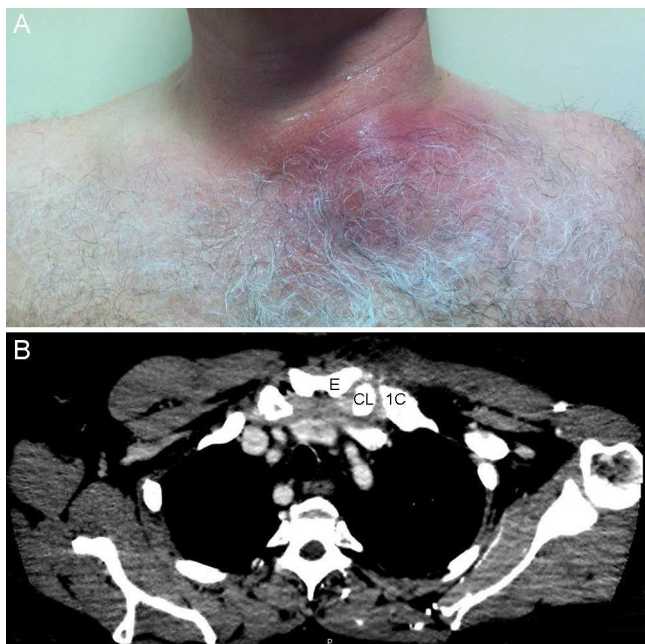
Case 5. (A) outward appearance. (B) CT of the thorax, showing the sternoclavicular joint capsular distention and inflammatory contents inside. (C) clavicle; (E) sternum; (1C) first rib.
